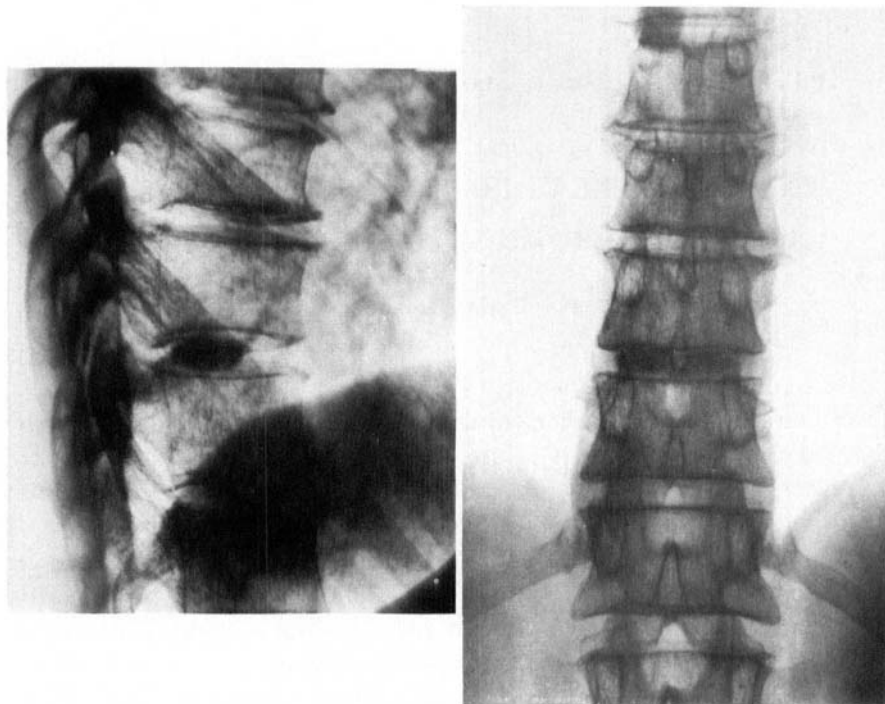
Radiograph showing calcification in intervertebral disc Th 10-11. Height of the intervertebral space 10 mm.
